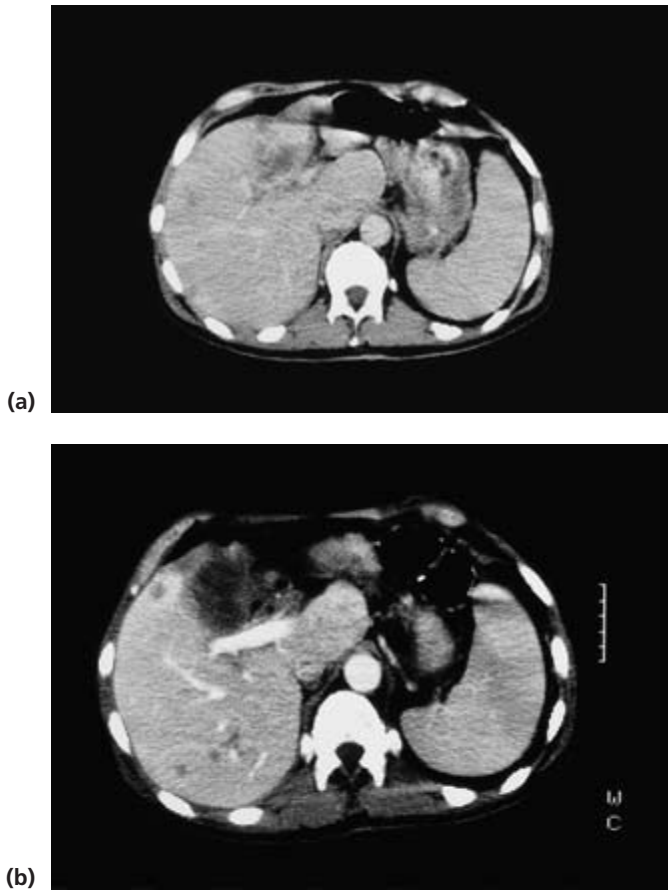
Value of CT portography. (a) Conventional enhanced CT scan of the liver in a patient with cholangiocarcinoma in the left lobe. There was a suspicion of metastases in the right lobe. (b) CT portography clearly showing multiple small metastases in the right lobe. The portal vein is well seen as is the lesion in the left lobe.
